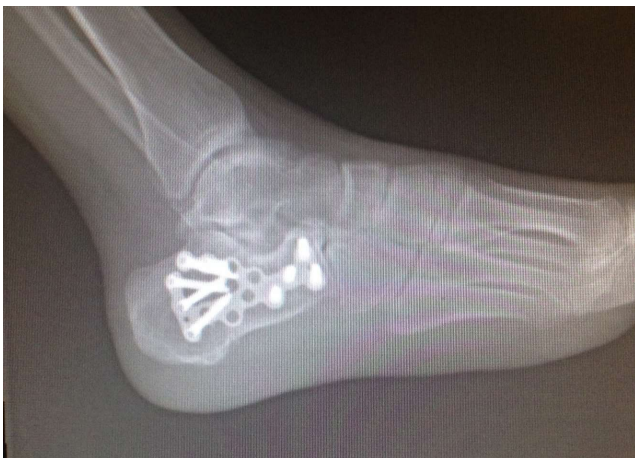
Lateral radiographic view at the postoperative 23rd month.
